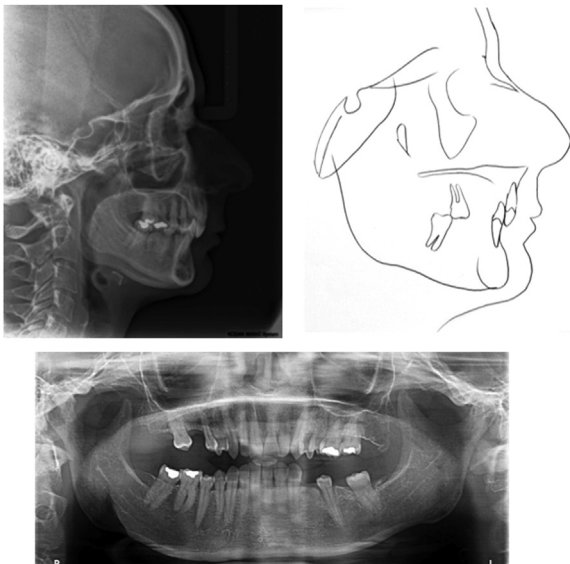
Patient 2. Pretreatment lateral cephalometric radiograph, tracing and panoramic radiograph.
